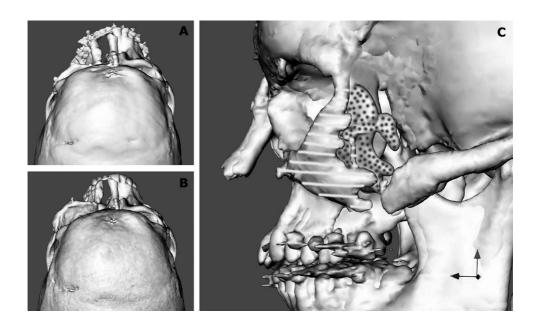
(A) 3D-CT scan (patient aged 16 years) before hemi-Le Fort III distraction, showing a hypoplasia of the left maxilla and zygoma in three dimensions.
